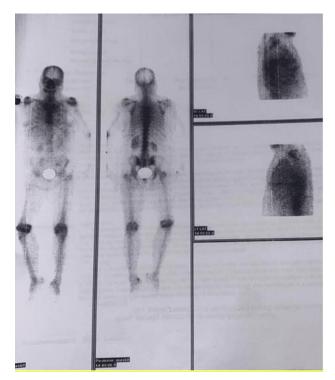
Skeletal scintigraphy showed homogenous and symmetrical tracer uptake indicative of non-metastatic carcinoma.
